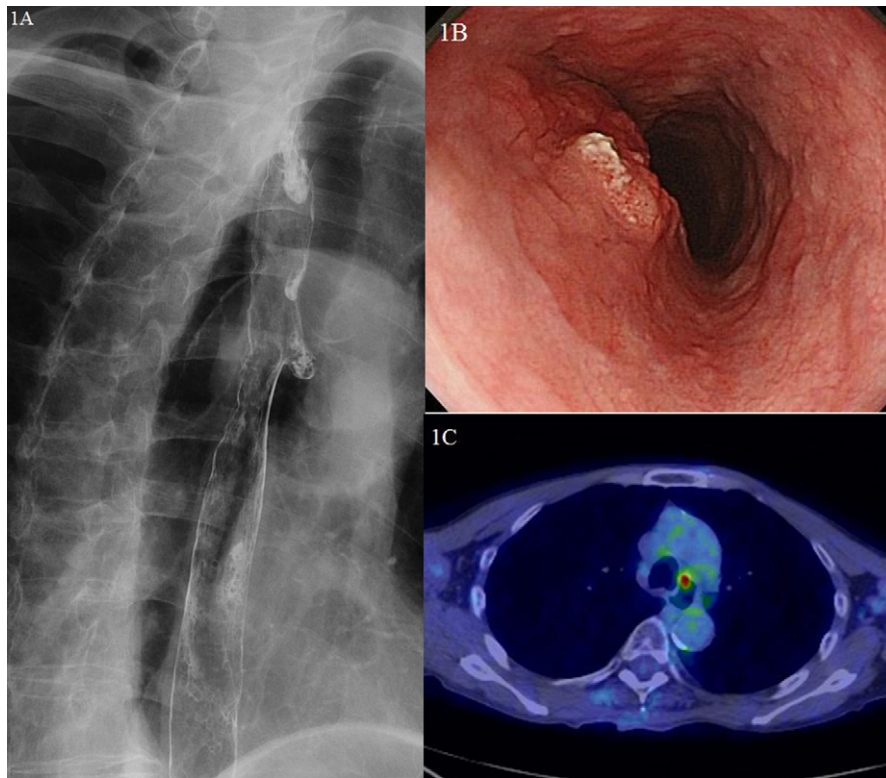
(A) Barium swallow showing a diverticulum below the aortic arch and the irregular outline of the mucosa. (B) Esophagogastroscopy showing an elevated lesion in the left wall of the esophagus. (C) FDG-PET showing a tumor (SUVmax = 5.0) arising from the diverticulum.
